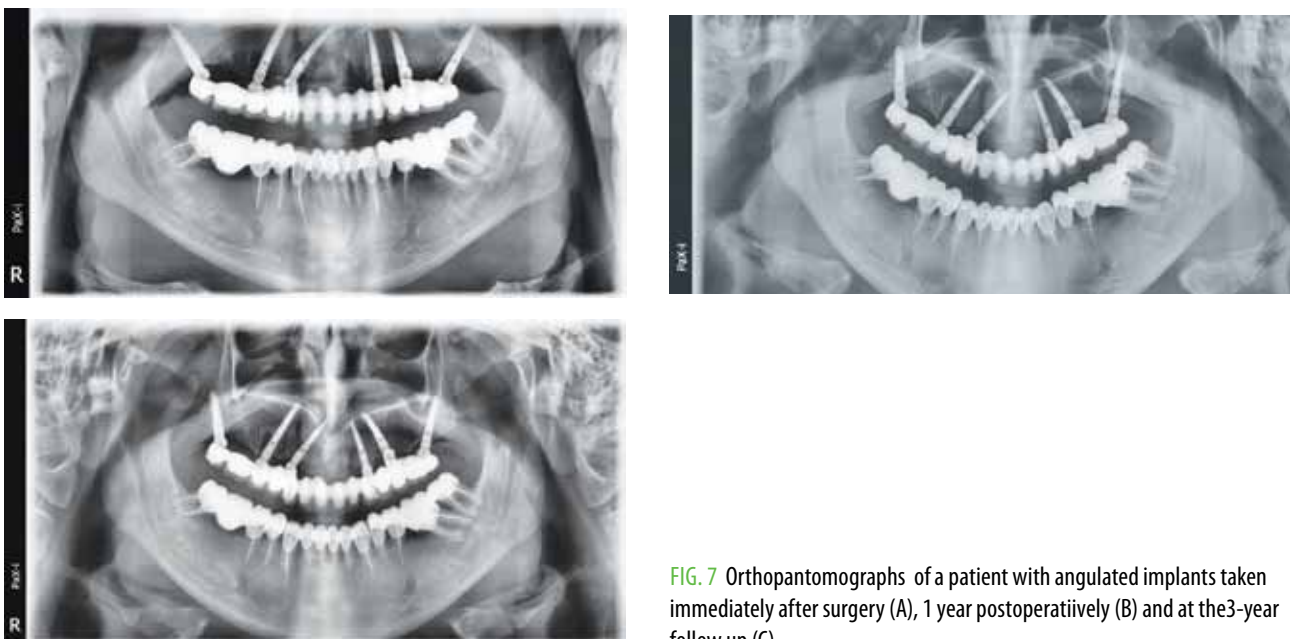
Orthopantomographs of a patient with angulated implants taken immediately after surgery (A), 1 year postoperatively (B) and at the 3-year follow up (C).
